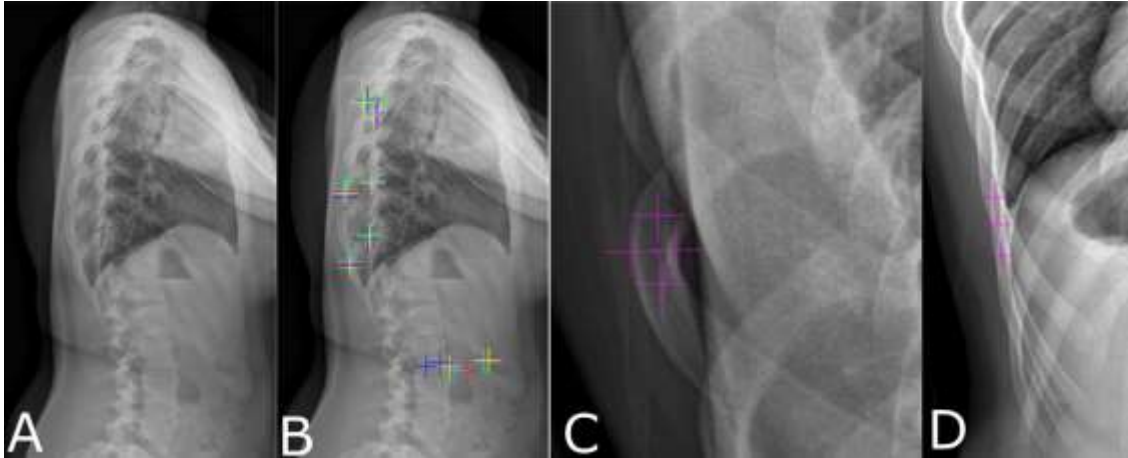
(A) Original lateral x-ray and (B) source of reproducibility issues for points identification of anatomical landmark for different users (one colour each). (C) Examples of possibilities for the identification of most posterior point or (C) most lateral points.
